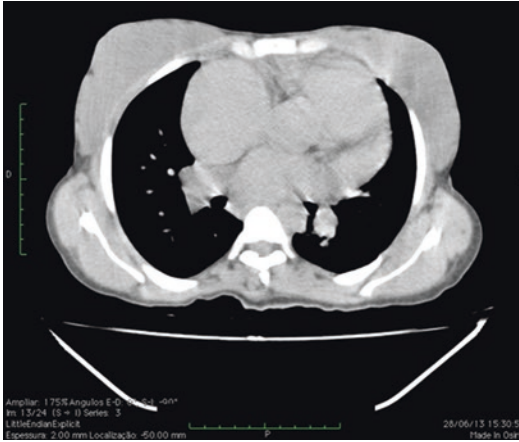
Computed tomography of the chest showing the following: projection of the sinus of Valsalva emerging and invading the right atrium; ascending aorta; dilatation of the main pulmonary artery
